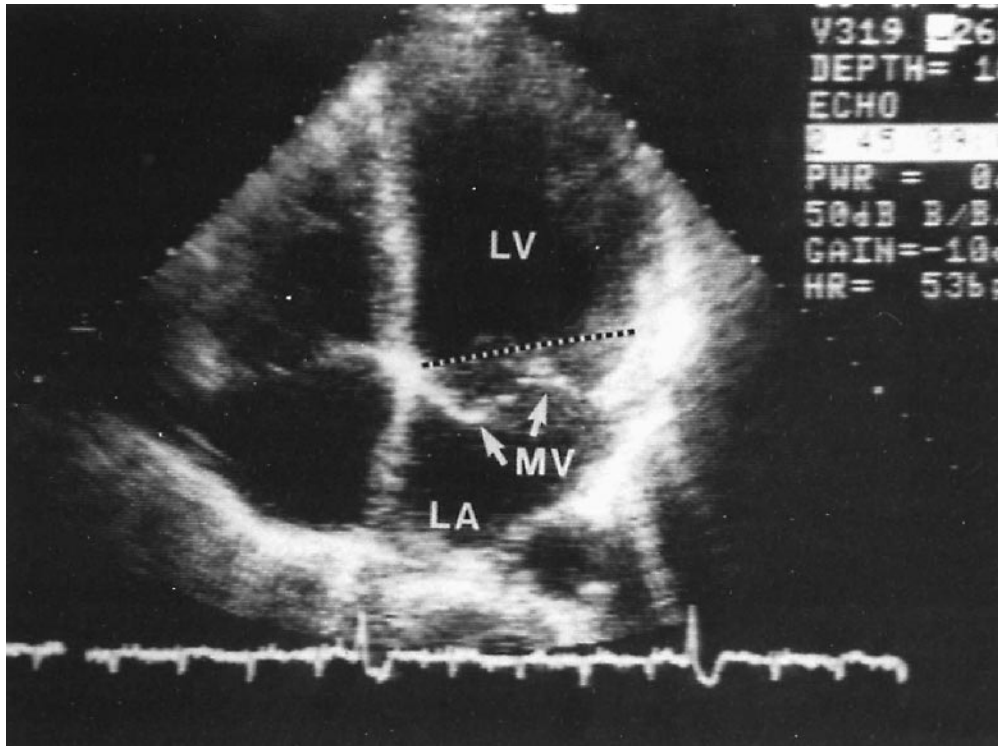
Two-dimensional echocardiogram (apical four-chamber view) demonstrating thickening and prolapse of leaflets above annulus plane. LA = left atrium; LV = left ventricle; MV = mitral valve. (Reprinted with permission from Ref. 119.)
